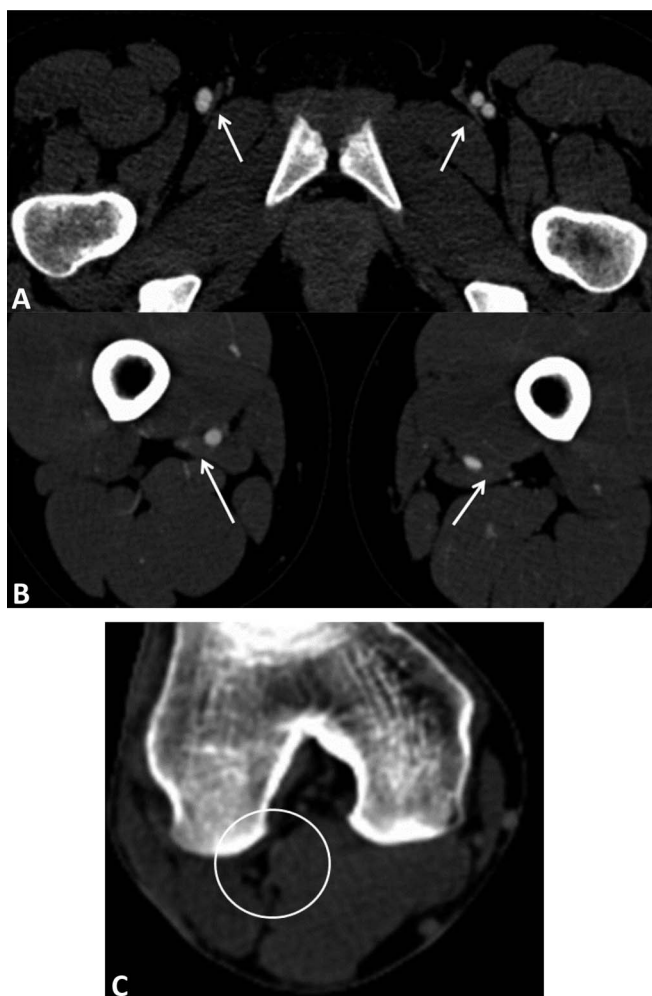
Location of venous compression varied among patients. A, Axial CTA images at the groin demonstrate femoral vein compression by the pectineus muscle (arrow). B, Axial CTA images at the level of the mid to distal femur demonstrate femoral vein compression in the adductor canal by the adductor longus muscle bilaterally (arrow) with mild compression of the femoral artery on the left. C, Axial CTA images at the level of the popliteal fossa demonstrate complete compression of the popliteal artery and vein by the medial and lateral head of the gastrocnemius muscle (circle). CTA, CT angiography.
